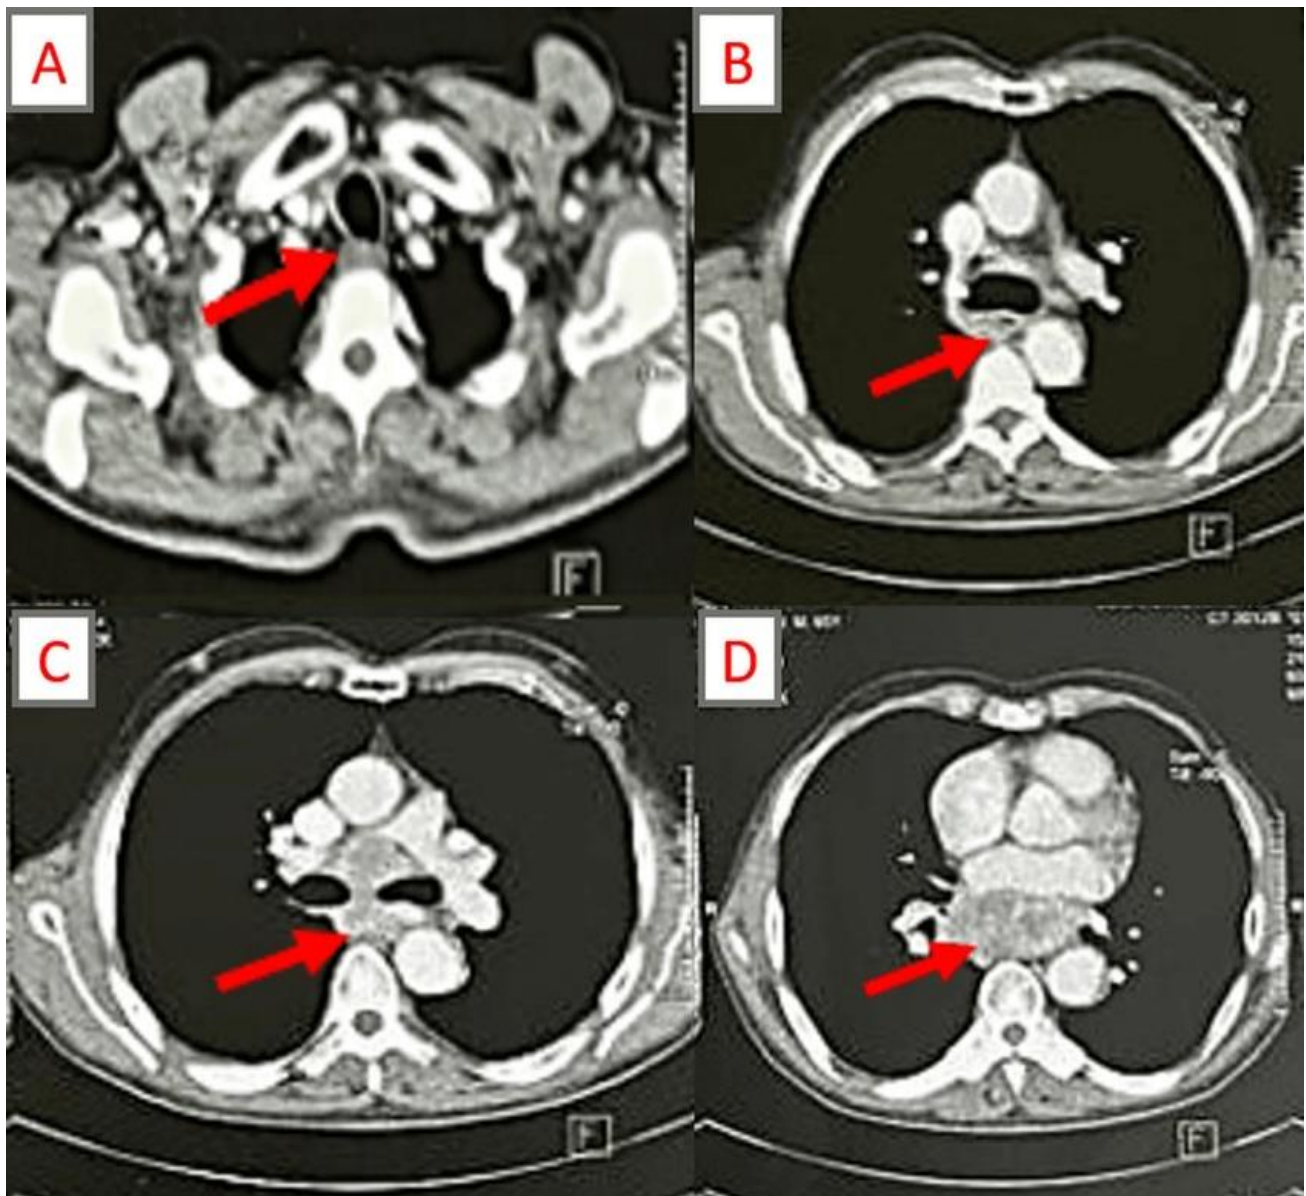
Axial contrast-enhanced thoracic computed tomography : Demonstrating a large posterior subcarinal mediastinal mass (red arrows); (A) Axial section at the thoracic inlet level showing the posterior mediastinal component of the lesion; (B) Axial section at the upper thoracic level demonstrating esophageal invasion associated with tracheal compression; (C) Axial section at the mid-thoracic level showing invasion of both pulmonary arterial branches and extension to the esophagus; (D) Axial section demonstrating close contact between the lesion and the left atrium, with significant extrinsic compression of the atrial cavity
